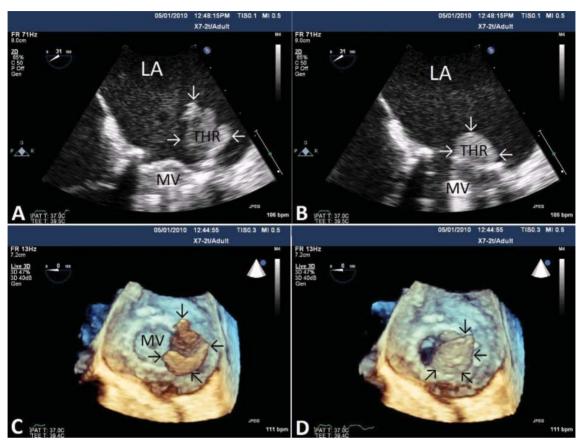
(A) Two-dimensional transesophageal echocardiography (TEE) image with a giant mobile thrombus located on the prosthetic mitral valve, prolapsing into left atrial cavity during systole and (B) obstructing the mitral inflow during diastole. (C) Real-time three-dimensional TEE clearly demonstrating a huge thrombus with two mobile components moving up and down during systole and (D) diastole (LA: Left atrium, LV: Left ventricle, MV: Mitral valve, THR: Thrombus, Arrows show the thrombus).
